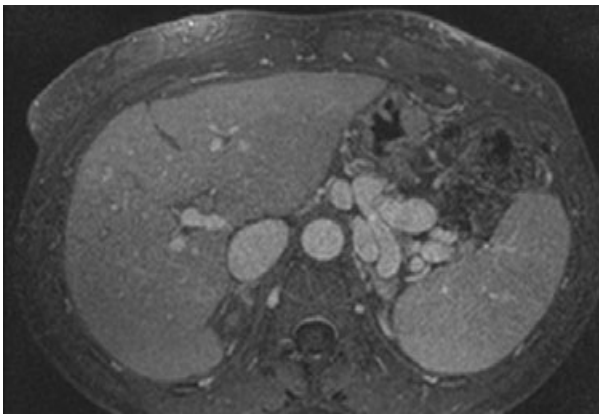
Magnetic resonance imaging. Splenomegaly and formation of large splenorenal shunt.
